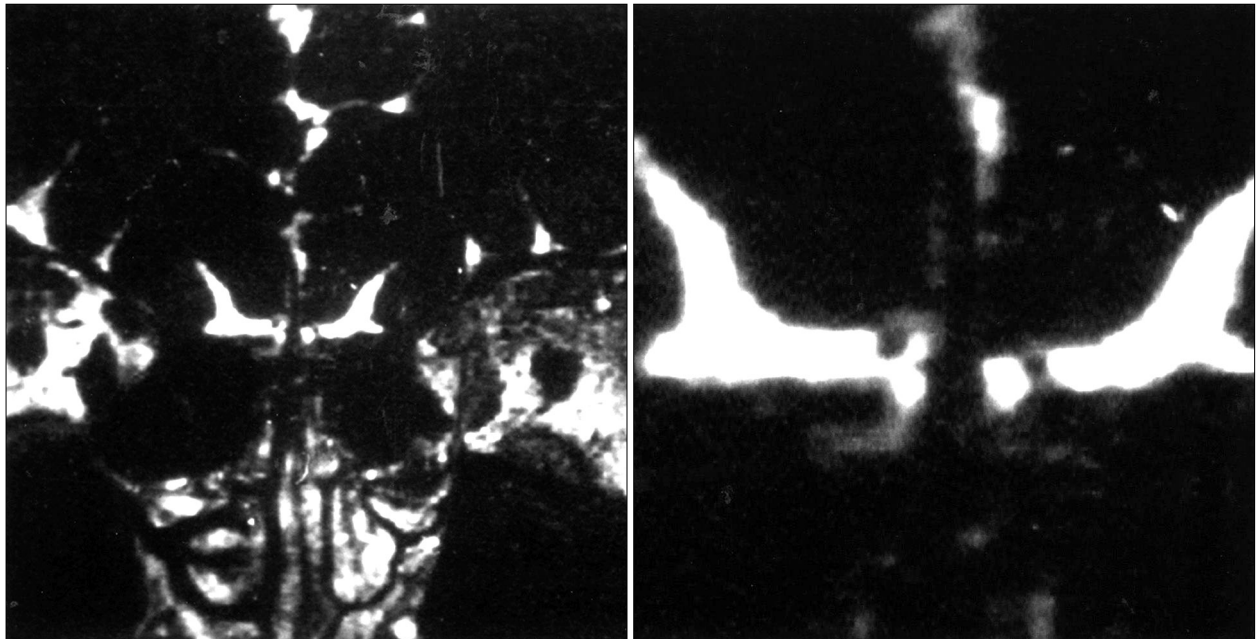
Magnetic resonance imaging of one anosmic patient demonstrating atrophy of olfactory bulbs on both sides. Its signal intensity is slightly lower than that of cerebral cortex.
